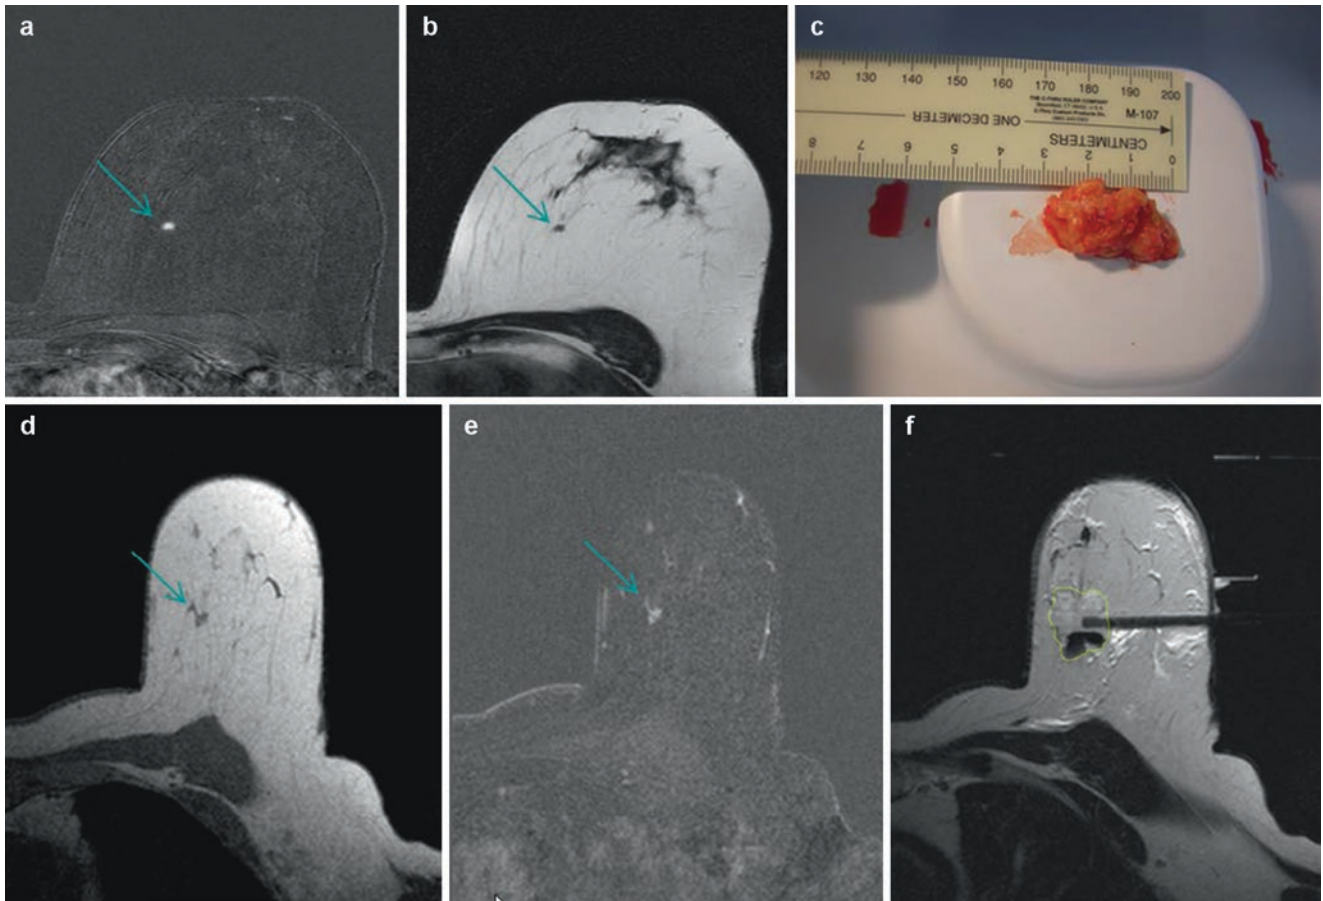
MR-guided vacuum-assisted large-volume breast biopsy (VALB). (a) FAST image that highlights a small enhancing lesion in the upper inner quadrant, 4 mm in longest diameter. (b) Corresponding T2-weighted structural image. (c) T1-weighted image prior to contrast injection during the intervention. (d) Corresponding post-contrast subtracted image reveals the target lesion. (e) T2-weighted image after
